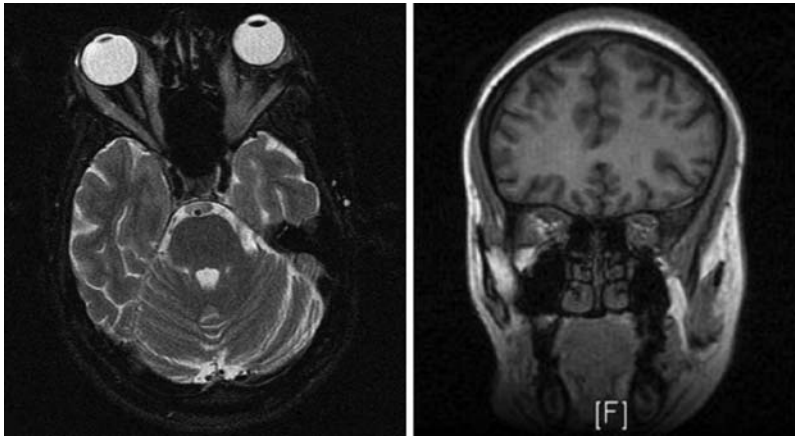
Orbital MRI demonstrating bilateral proptosis, enlarged ocular muscles, and compressive optic neuropathy. (A) Axial view; (B) coronal view.
